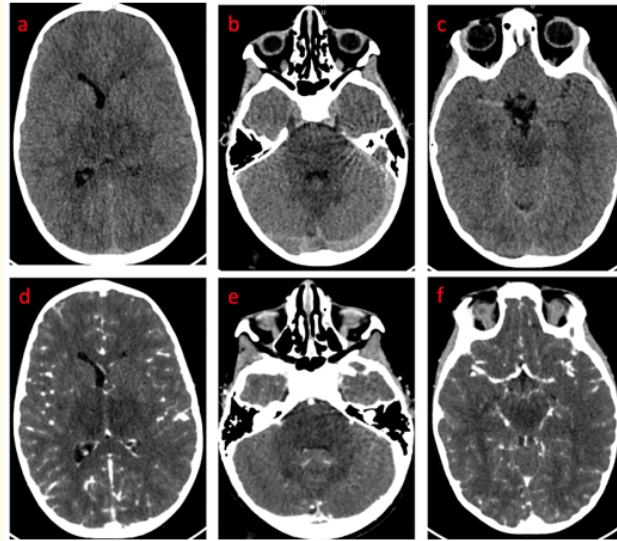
CT scans before (a; b; c) and after contrast administration (d; e; f) showing bilateral, symmetric mass-like hypodensity involving the thalamic nuclei, the posterior capsulo-lenticular regions, the mesencephalic and pontine structures, and the middle cerebellar peduncles.
